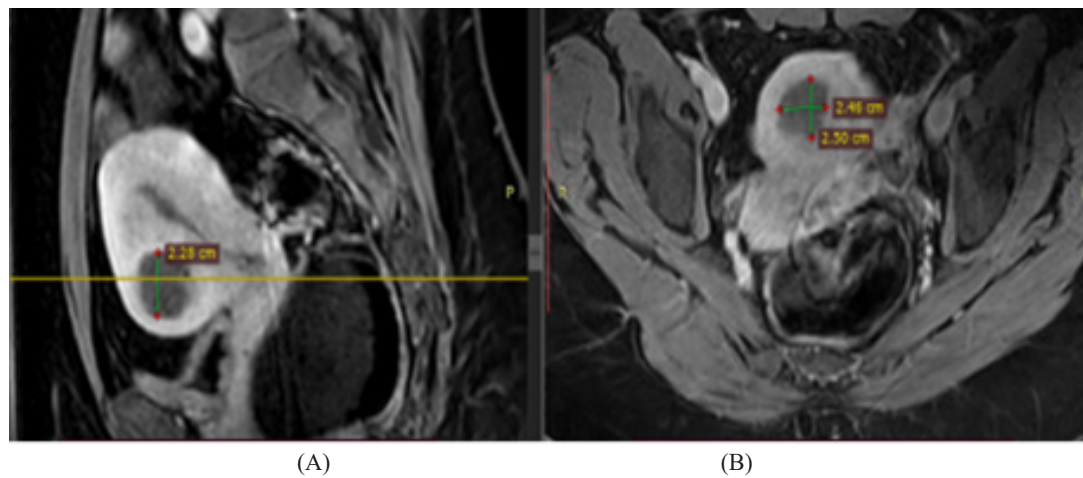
A 42-year-old female presented with Heavy continuous menstrual bleeding, she underwent one MR-HIFU session, and now the patient reports significant relief in the symptoms. The cycle has returned to normal. Sagittal (A) and Axial (B) T2 MRI image demonstrates an interstitial anterior wall myoma, showing dark signal denoting FUNAKI-type I with homogenous enhancement in T1 post contrast image. Total myoma volume before HIFU = 19 cc.
